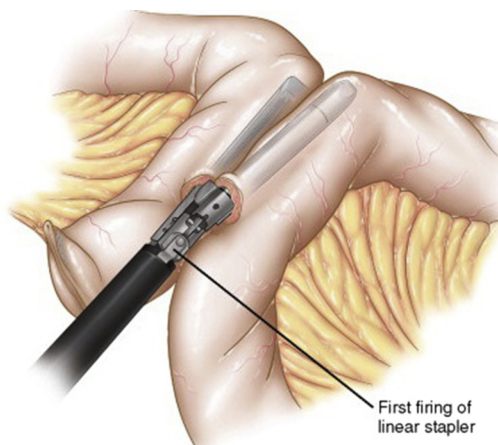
A white 2.5-mm staple load is used to join together the two loops of bowel. (From Zografakis JG, Frantzides CT. Laparoscopic Gastric Bypass with Roux-en-Y Gastrojejunostomy. In: Frantzides CT, Carlson MA, editors. Atlas of Minimally Invasive Surgery. Philadelphia: Elsevier Saunders; 2009. p. 53–66; with permission.)
